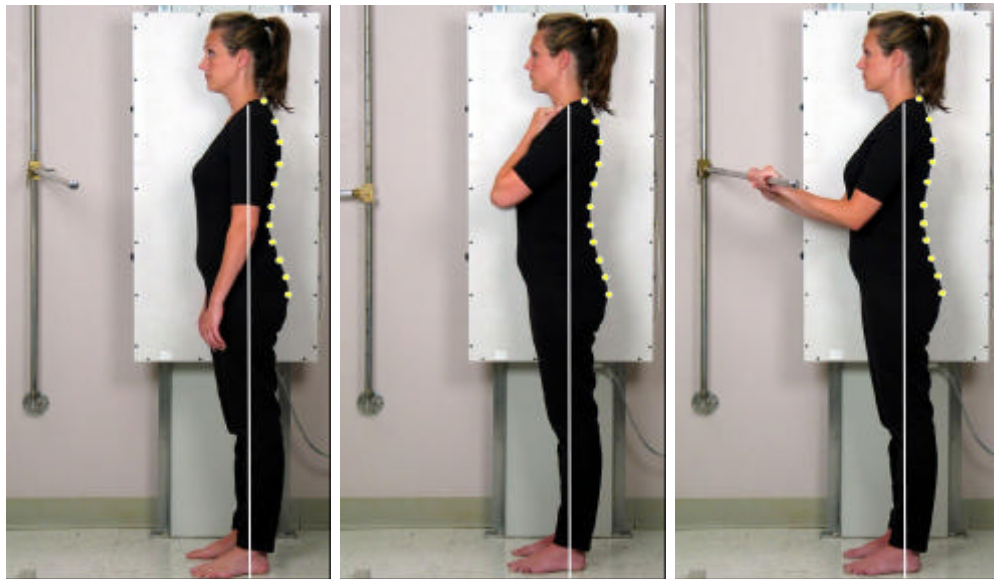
Clinical examples of patient positioning for standing radiograph of the entire spine. Obtained from Jackson, RP, et al. Sagittal Spinopelvic Alignment: Comparison between Japanese and American Volunteers, Power Point Presentation, World Spine II, Chicago, August 2003.
